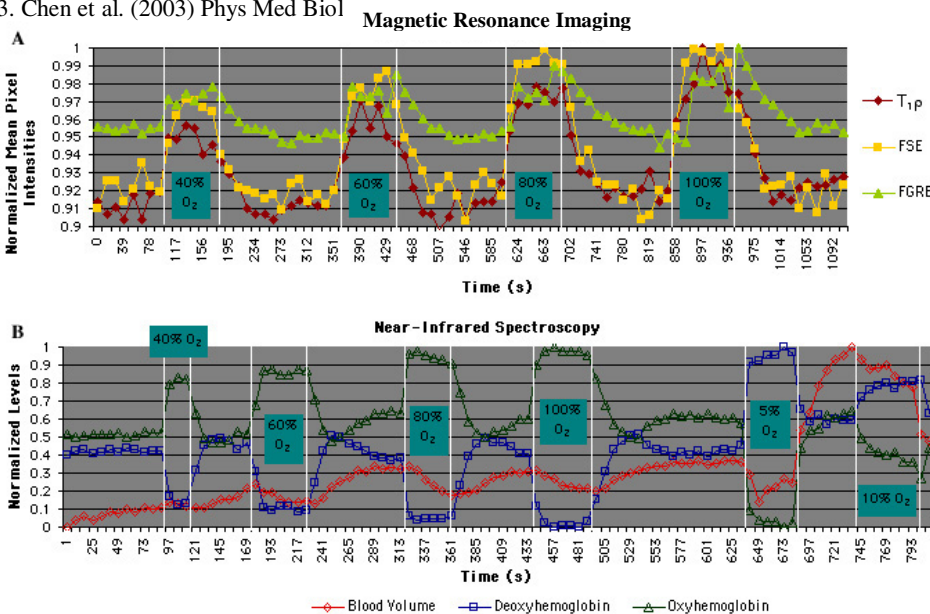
(Left) $T_{1\rho}$ -weighted, FSE, an FGRE MRI and NIRS data compared. The unlabeled regions are 20% O_2 and 80% N_2 .
